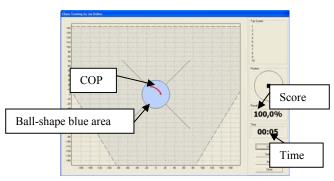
CT program on computer screen
